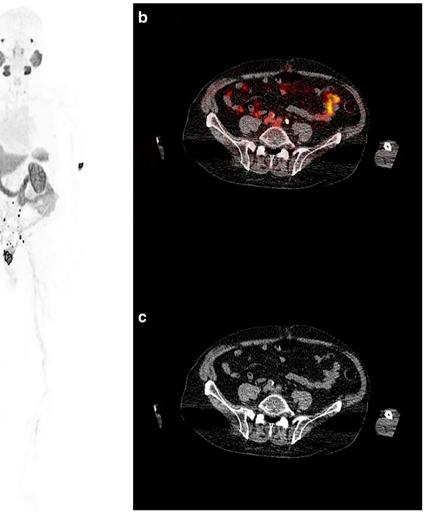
A 79-year-old patient was referred to our department due to biochemical progression of PC and PSA elevation at 7.28 ng/mL. The patient was treated with radical prostatectomy and androgen deprivation therapy. ¹⁸F-PSMA-1007 PET whole-body maximum intensity projection (MIP) (a) demonstrates multiple foci of increased tracer uptake in the abdomen and pelvis, corresponding to several lymph node metastases and a local relapse. Transaxial, fused ¹⁸F-PSMA-1007 PET/CT at the pelvic level (b) shows a focal site of increased tracer uptake, corresponding to an iliac lymph node. Transaxial low-dose non-enhanced CT at the same level (c) shows no pathologic enlargement, at the anatomical site of the tracer
